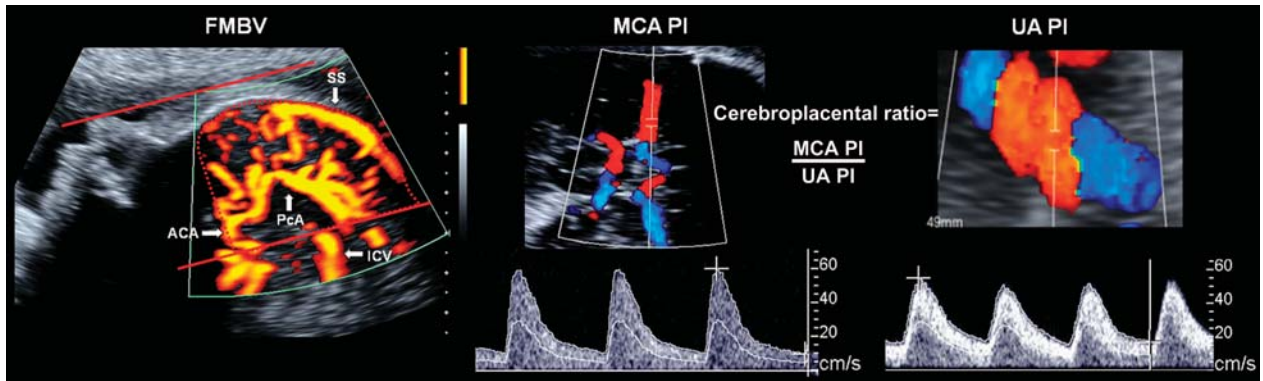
Spectral and power Doppler parameters. FMBV, fractional moving blood volume; MCA, middle cerebral artery; PI, pulsatility index; UA, umbilical artery; SS, sagittal sinus; Pca, pericallosal artery; ACA, anterior cerebral artery; ICV, internal cerebral vein.
